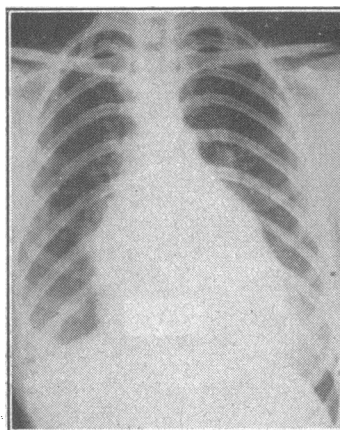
Chest x-ray film of patient with mitral stenosis.
